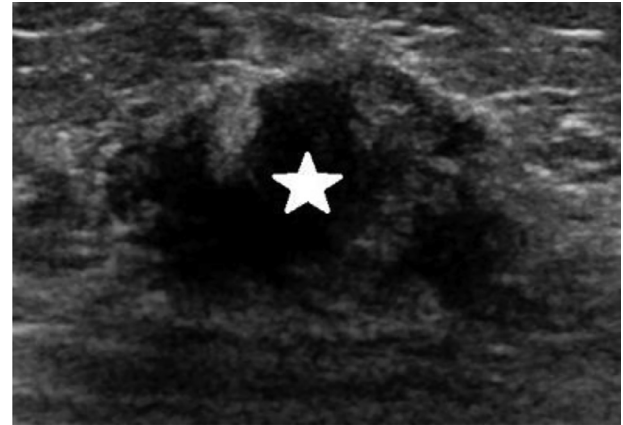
Also in August 2020, an additional oval, irregular mass with angular margins (star) was noted at 3:00 3 cm from the nipple measuring 1.5 × 0.9 × 0.9 cm. This was also given a BI-RADS 5 assessment and ultrasound-guided core biopsy was performed.
